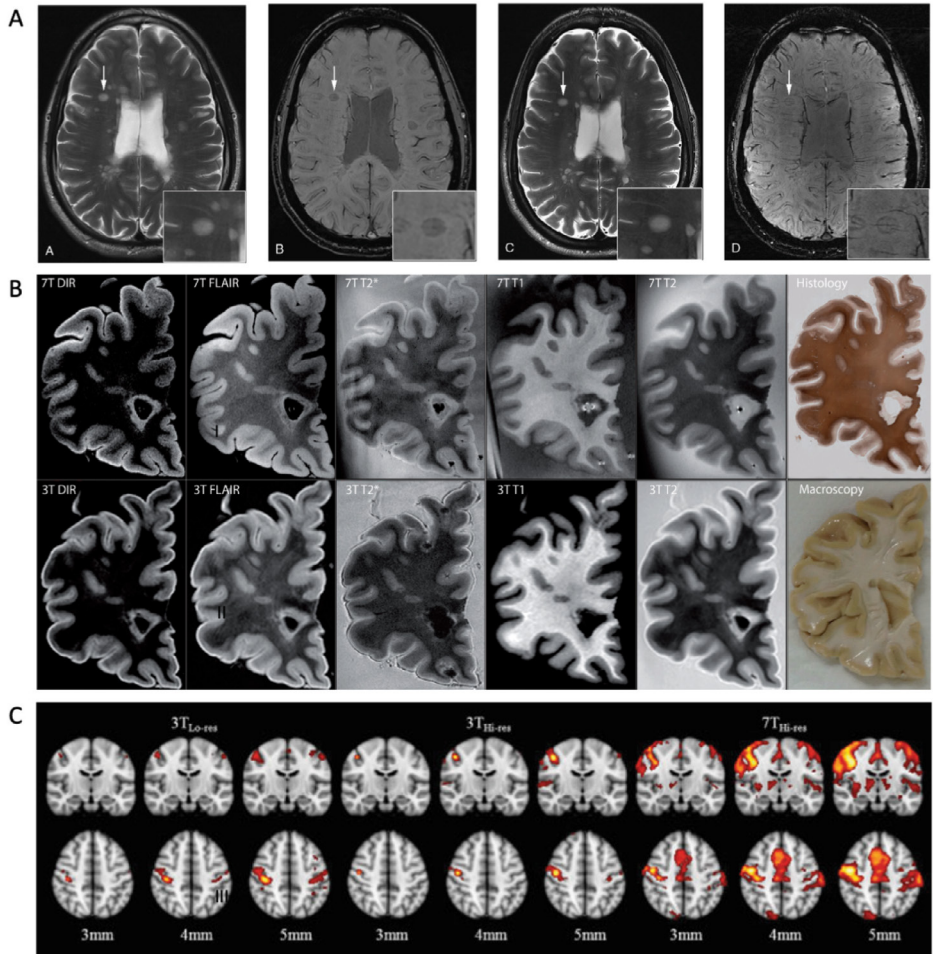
Functional and structural imaging at 3T and 7T in multiple sclerosis. A) Comparison of routine T2-weighted imaging at 3T (A.A) and 7T (A.B) and corresponding axial susceptibility weighted images (SWI) at 3T (A.B) and 7T (A.D).⁸⁹ The white arrow indicates the central vessels in MS white matter lesions which are easier and more clearly depicted on 7T compared to 3T SWI. Image adapted from Springer et al. 2016.⁸⁹ B) A single brain slice of an MS patient acquired at 7T and 3T using multiple sequences including double inversion recovery (DIR), fluid attenuation inversion recovery (FLAIR), T2*, T1-weighted and T2-weighted.⁹⁴ Compared to 3T, higher field imaging resulted in improved quality and grey matter lesion detection. Detected lesion were verified post-mortem. Image adapted from Kilsdonk et al. 2016.⁹⁴ C) Compared to 3T, a higher field strength and lower spatial smoothing improves the spatial specificity of connectivity maps and results in the identification of motor cortices. Image adapted from Hale et al. 2010.⁹²
